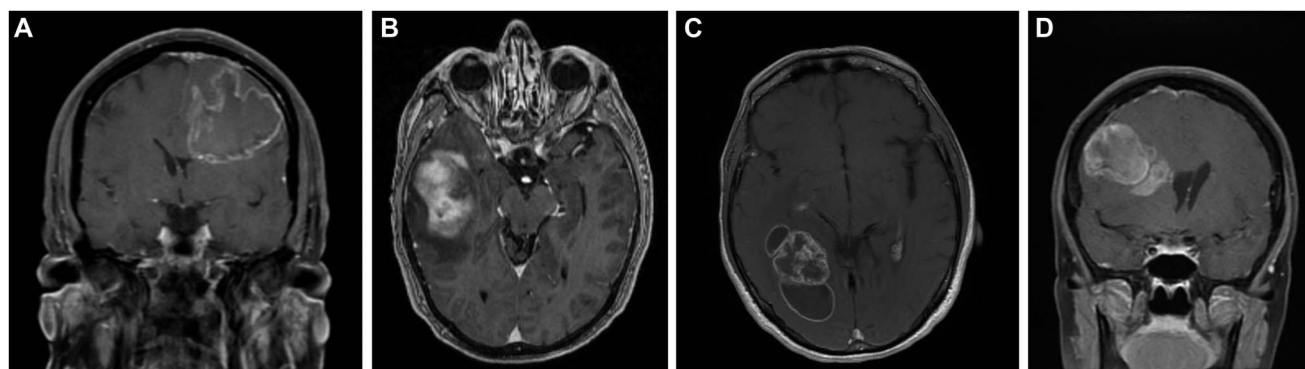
Magnetic resonance images demonstrating glioblastoma contiguous with subventricular zone, A-D.
